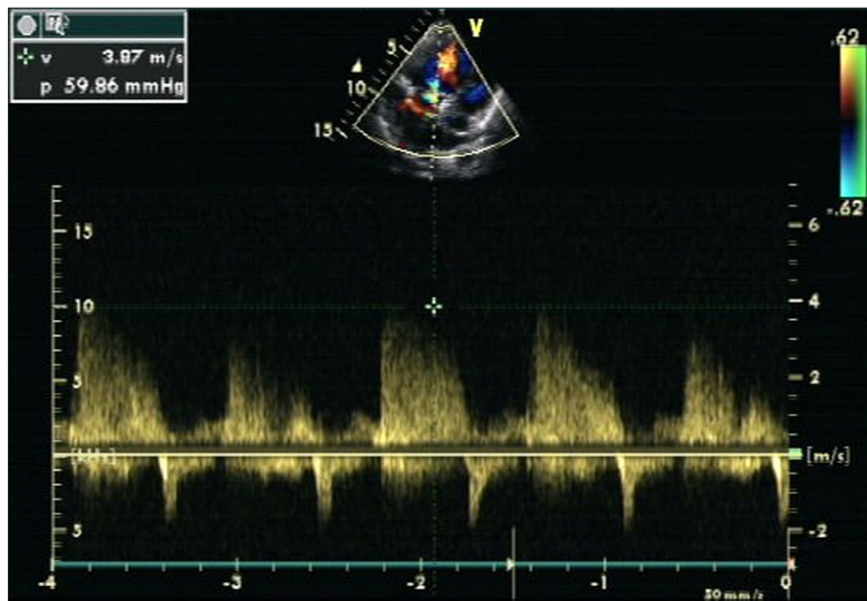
Continuous wave Doppler echocardiography in Case 1. Severe regurgitation in pulmonic valves, and moderate regurgitation in tricuspid and mitral valves.
